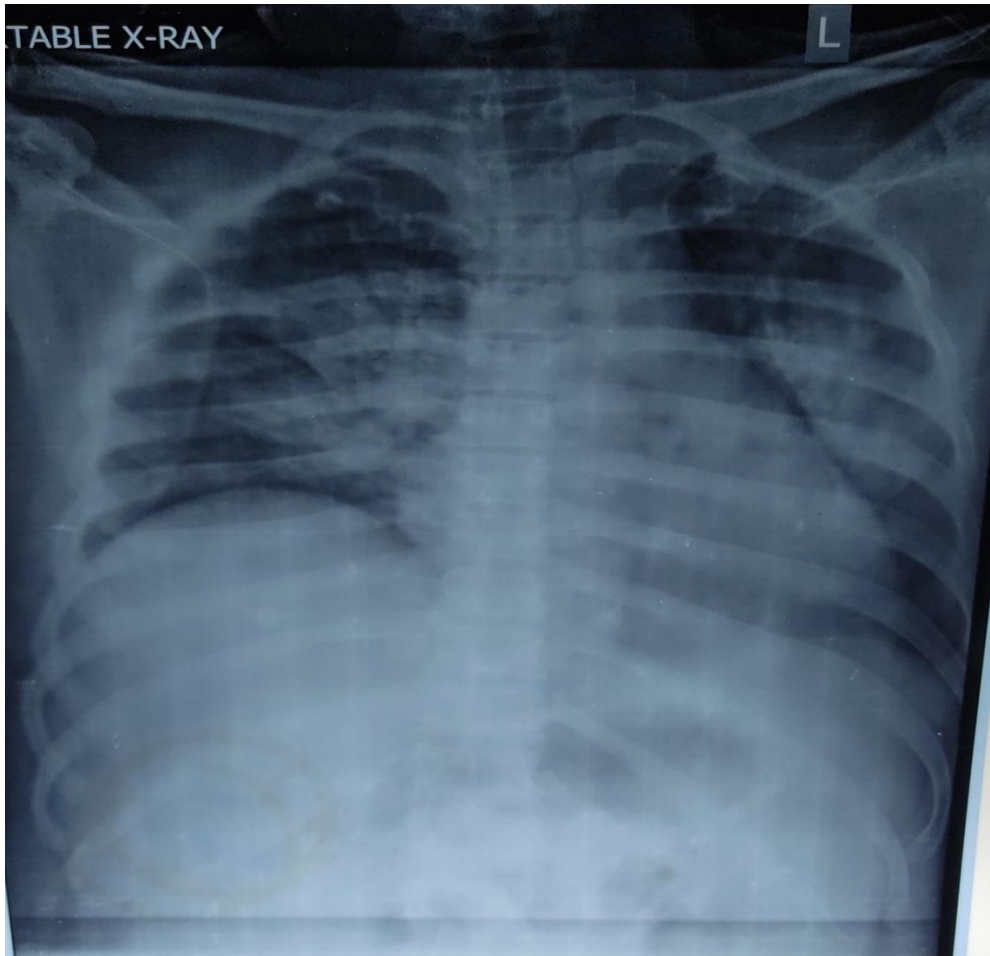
chest radiograph showing acute respiratory distress on the 2nd day.
